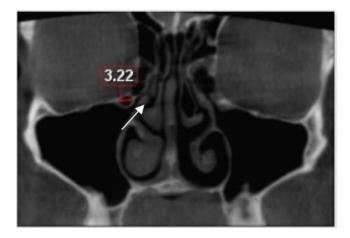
Coronal cone beam CT shows, measurement of Haller cells (arrow)
